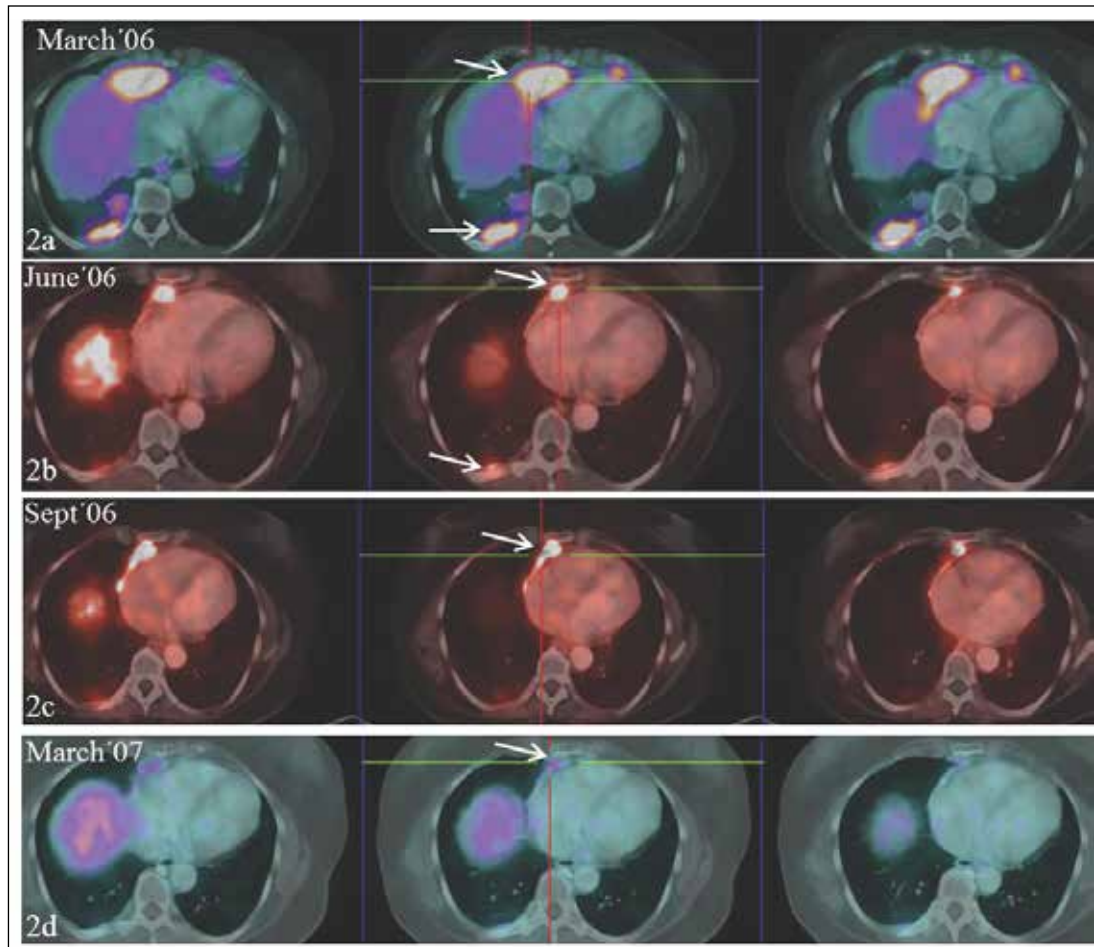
Serial axial fused ^{68}Ga DOTATOC positron emission tomography/computed tomography images (March 2006 to March 2007). (A) Pericardial and pleural deposits (arrows) in the baseline scan in March 2006. (B) Received the first PRRT in March 2006, and a partial response was observed in June 2006, with tracer-avid residual pleural and pericardial metastatic deposits (arrows). (C) Stable disease seen in September 2006 (arrows). (D) Received the second PRRT in October 2006, and a near complete metabolic and morphological response was seen in March 2007, with a small residual pericardial nodule noted (arrow). PRRT = peptide receptor radionuclide therapy.
